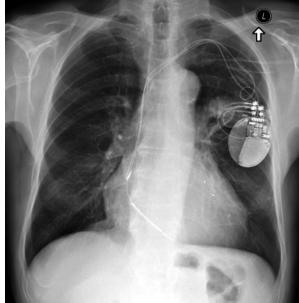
The posteroanterior chest X-ray taken after TLE procedure
